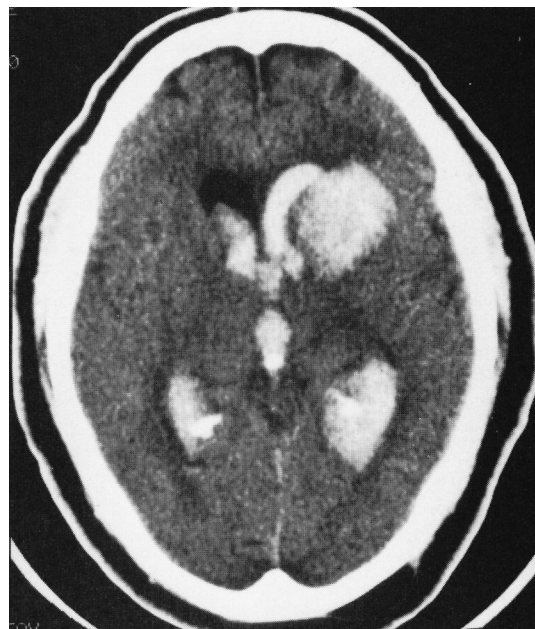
Head CT demonstrating hemorrhagic infarct.
